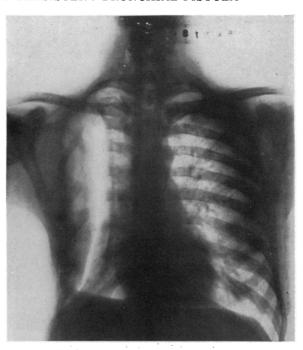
Case II. X-ray following closure of the empyema wound showing the layer of air between the visceral pleura and the overlying chest wall.
